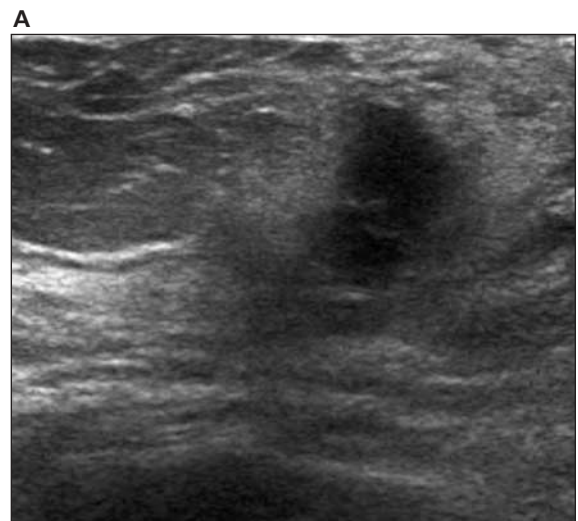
Palpable lump in the left breast in a 50-year-old woman. A mammogram taken at the private clinic showed a focal asymmetric density (not shown). A, Sonography shows a 10-mm irregular hypoechoic nodule, spiculated, not parallel in orientation, in the corresponding area of the left breast on the mammogram. B, After the first firing of the 14-gauge biopsy needle, the nodule shrank. The core needle biopsy revealed a galactocele.
